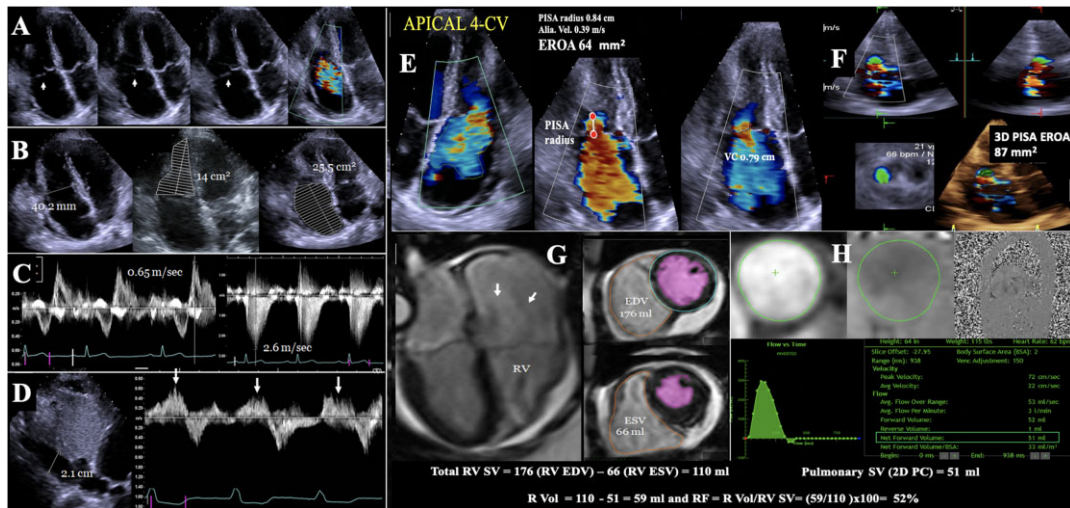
Assessment of TR severity and consequences compiling 2D/3D echocardiography and CMR data.
